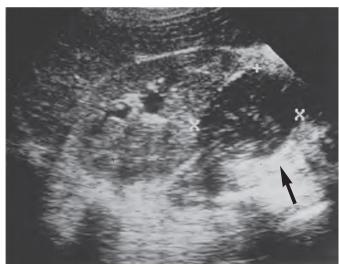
Perinephric abscess. Ultrasound examination reveals a perinephric abscess (arrow). (Courtesy Dr. M. Bergeron.)
